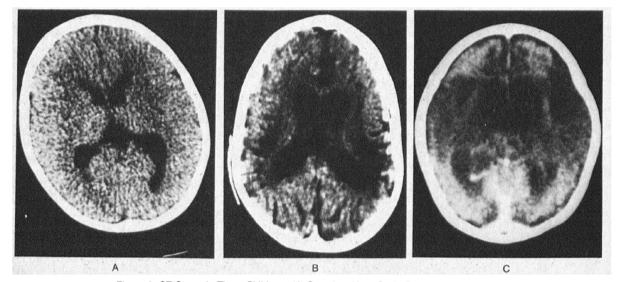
CT Scans in Three Children with Complete Urea-Cycle Enzyme Deficiencies.
